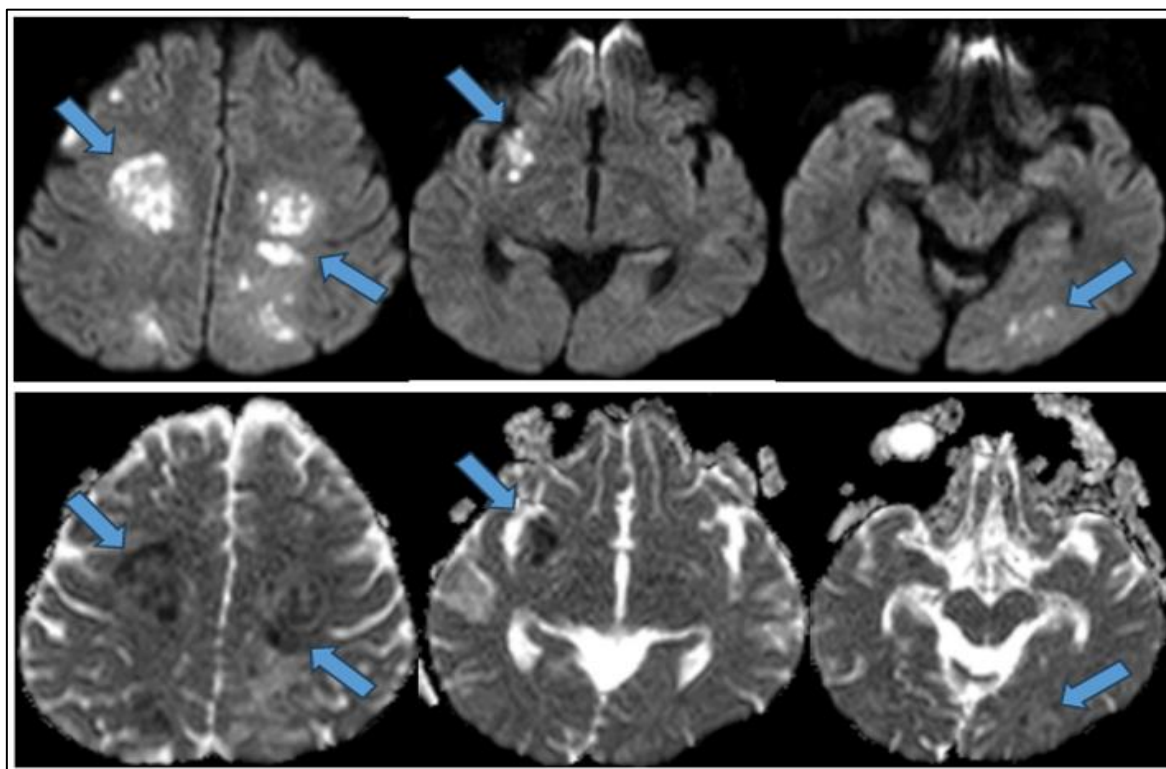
Axial DWI, Fig 2b: Axial ADC Sequences Showing Restriction of Diffusion in Centrum Semi Ovale on Both Sides, Right Anterior Temporal Lobe, Left Temporal and Occipital Lobes.
